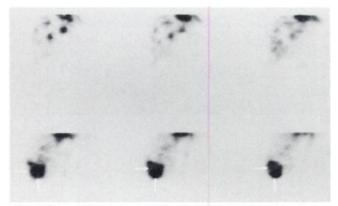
Coronal SPECT images of the liver demonstrate intense concentration of activity in the inferoposterior aspect of the right lobe of the liver. With SPECT imaging, the lesion (between arrows) is clearly distinguished from the adjacent normal liver.
